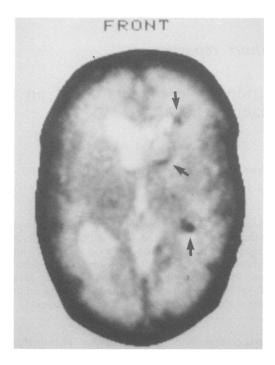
Computed tomogram seven days after surgery. Remaining blood clot is indicated by arrows.
